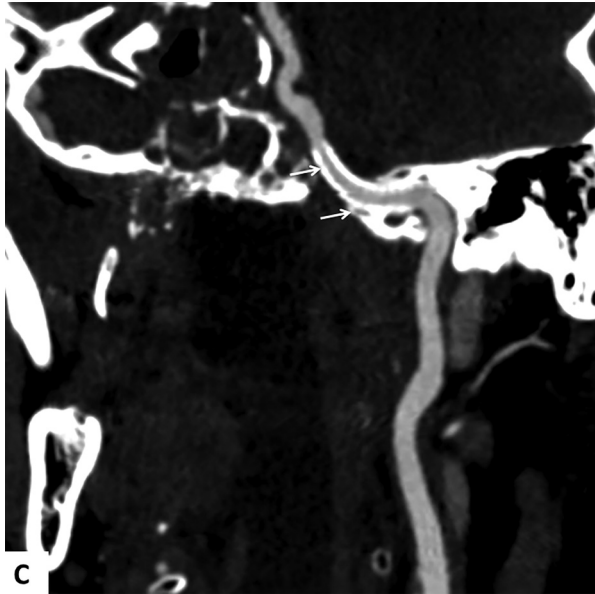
Follow-up CT angiography at 3 months after the stent graft placement shows patency of the left ICA with no pseudoaneurysm depicted (white arrows).
